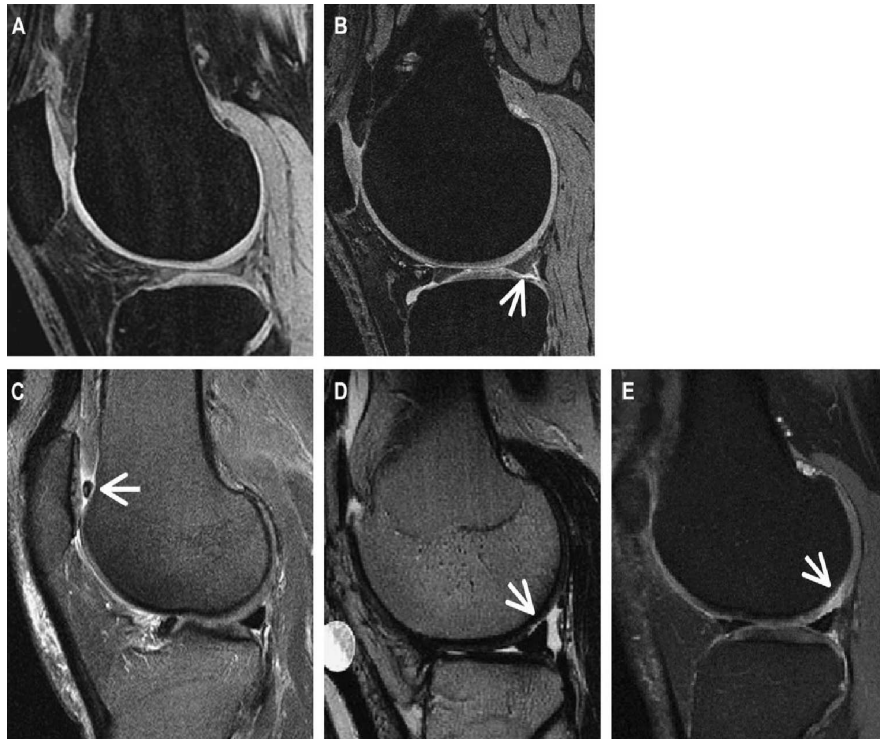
Cartilage contrast with various pulse sequences. (A) Sagittal fat-suppressed T1-weighted 3D GRE image depicting articular cartilage as a high-signal structure in sharp contrast against adjacent low-signal bone, marrow fat, intra-articular adipose, fluid, ligaments and menisci. (B) Sagittal 3D DESS image showing partial-thickness cartilage defect (arrow) over posterior lateral tibial. Note the similarities in contrast properties of fat-suppressed DESS with those of fat-suppressed FSE. (C) Sagittal fat-suppressed IW 2D FSE shows a loose body (arrow) in the patellofemoral compartment. (D) Sagittal T2-weighted 2D FSE image without FS shows a partial-thickness defect (arrow) of the lateral femoral cartilage adjacent to the posterior horn of the meniscus. (E) Sagittal fat-suppressed T2-weighted 2D FSE image of a different knee shows a partial-thickness cartilage defect (arrow) in a similar location (figure and caption reproduced from [79]).
